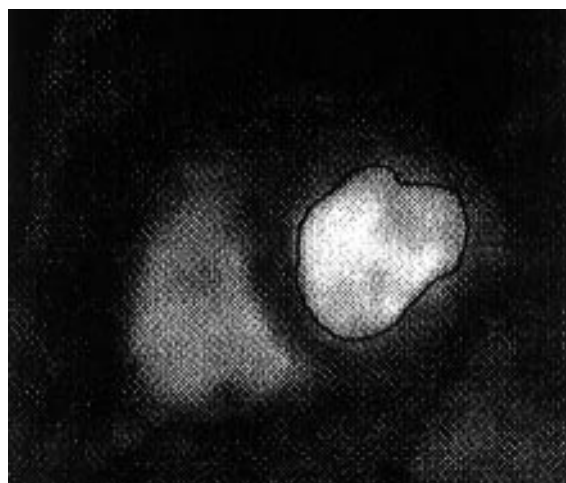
Expert's hand drawn contours of end-diastolic MR image of the middle of the heart (patient 1).
